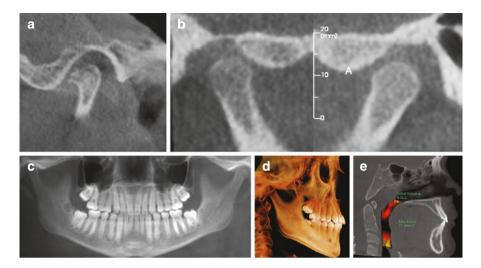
CBCT reformats for common diagnosis for anterior condylar position: (a) end-stage degenerative joint disease and (b–e) dual bite formation in order to increase oropharyngeal airway dimensions. (b) Cross sections show anterior position of normal contoured condyles; (c) panoramic reformat shows the teeth in maximum intercuspation with the condyles anteriorly positioned, a hallmark of dual bite formation; (d) lateral 3D reformat shows the flattening of the maxillary curve of Spee, indicating that the posterior teeth have supererupted after chronic anterior posturing of the mandible; and (e) airway reformation shows a narrow oropharyngeal airway, which may indicate that the reason for the anterior posturing of the mandible was to increase patency of the airway
